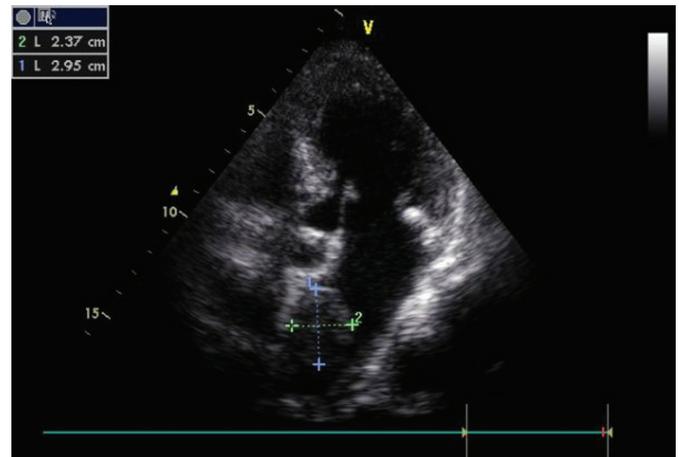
Two dimensional echocardiogram demonstrated a left atrial myxoma attached to the interatrial septum.
